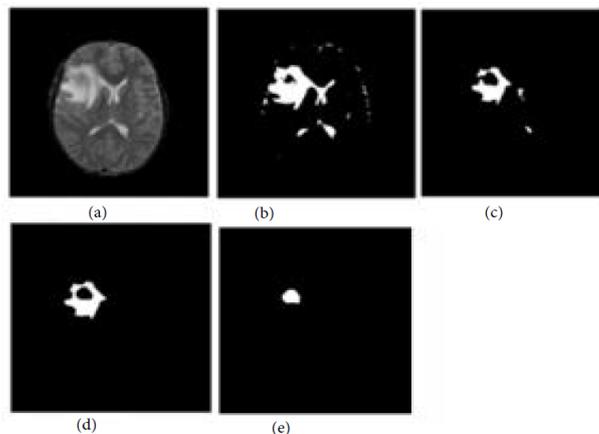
Different MRI outputs, including the original picture (a), the k-means segmented image (b), and the fuzzy inference version (c), are classified. the c-means segmented picture, the clear border image, and the feature extracted image
